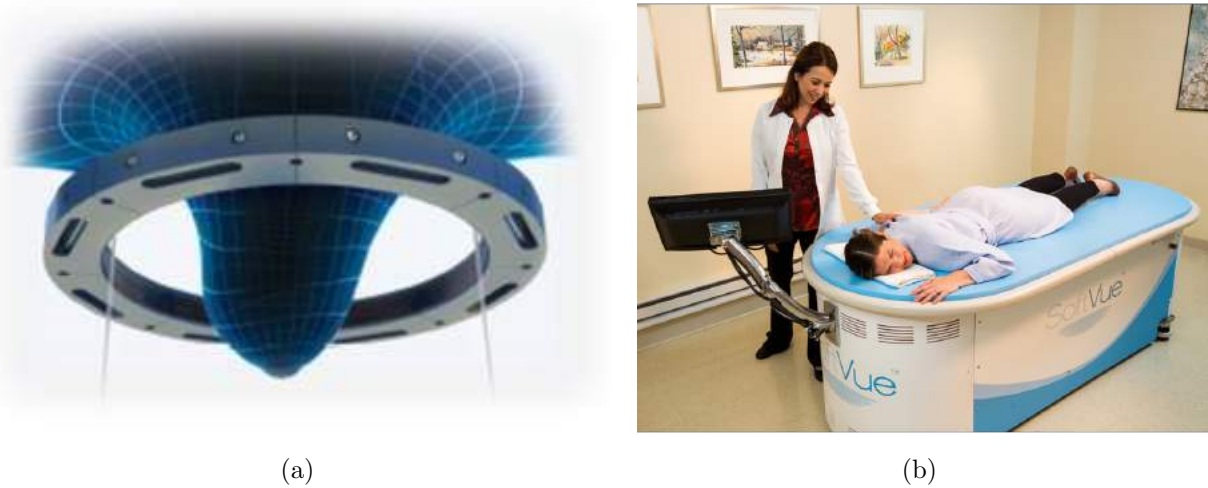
Ultrasound Tomography Breast Placement and Patient Scan. (a) Breast in ring. (b) Data acquisition.
